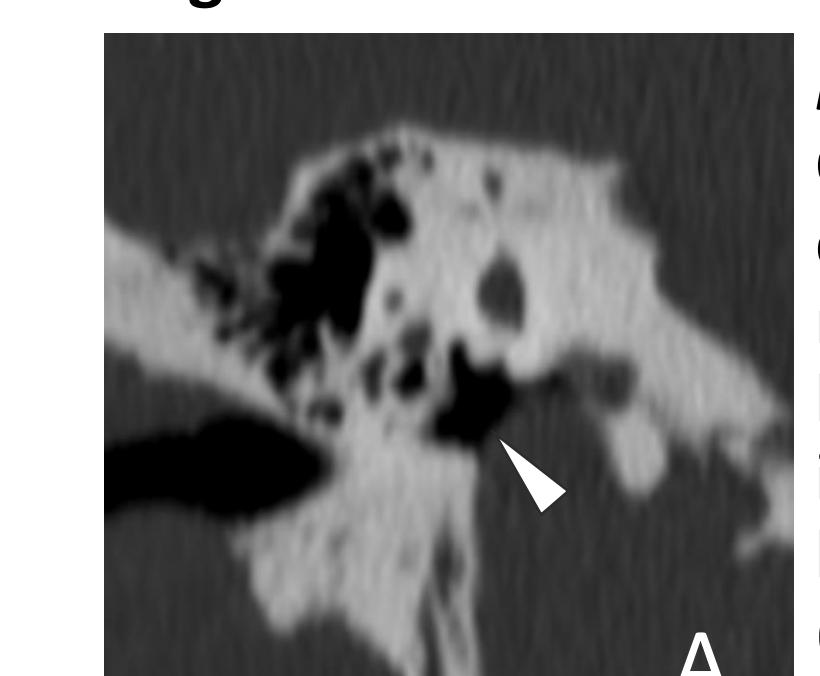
Axial CT shows a dehiscent high-riding jugular bulb protruding into the hypotympanum (arrowhead).
